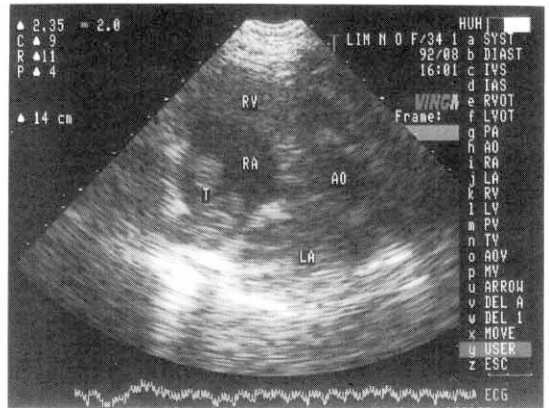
2-D echocardiography showing thrombus in the right atrium.
